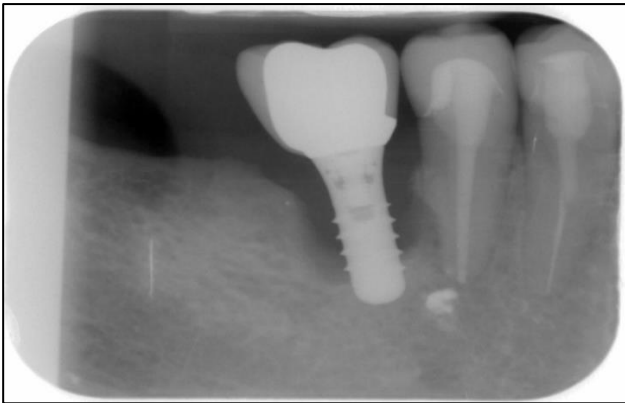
Pre-operative radiograph confirmed Peri-implantitis with >50% bone loss.
